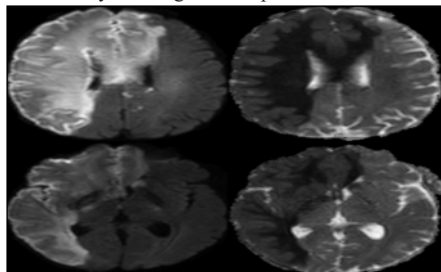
MRI Brain Showing Right Internal Carotid Artery Territory Infarct With Left Anterior Cerebral Artery Territory Infarct.
